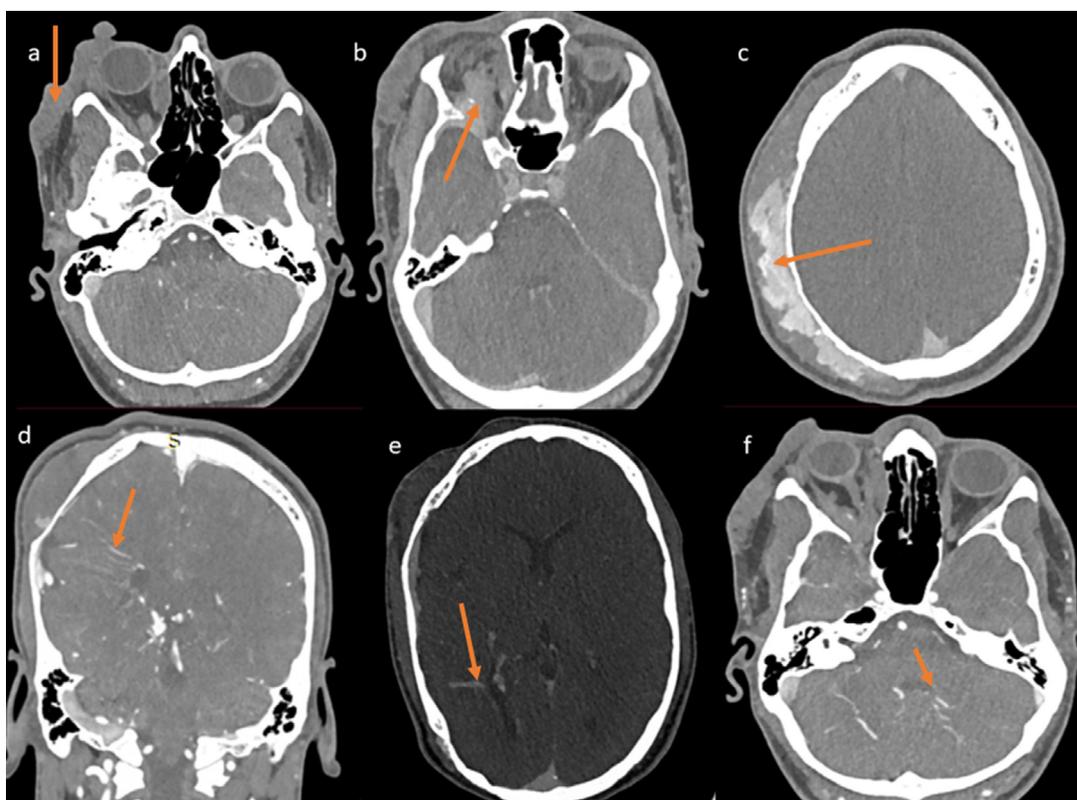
(a) Axial CT image shows nodular soft tissue thickening over the right periorbital and right temporal region (arrow). (b) Soft tissue nodular lesion also noted in the intraconal compartment of the orbit on right side. (c) Postcontrast axial CT in venous phase shows progressive enhancement of the soft tissue lesion in right frontoparieto-temporal region which is suggestive of a venous malformation (arrow). (d) Coronal CT venogram shows multiple prominent medullary veins (arrow) converging towards a common collector vein in right peritriangular region, suggestive of a developmental venous anomaly. (e) Another right peritriangular developmental venous anomaly is noted (arrow) on axial CT venogram. (f) Axial CT venogram shows developmental venous anomaly involving the left cerebellar hemisphere (arrow) which was seen draining into the Vein of Galen.
